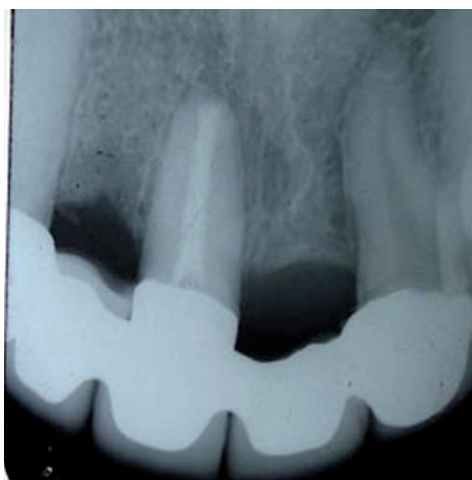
IOPA radiograph after cementation of definitive prostheses
